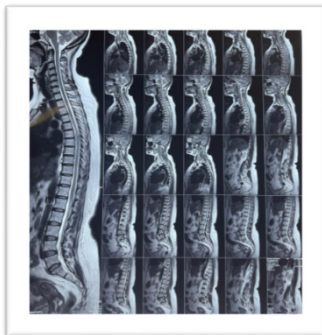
T2 – weighted sagittal MRI showing a mass consistent with meningioma at D6-D8.
